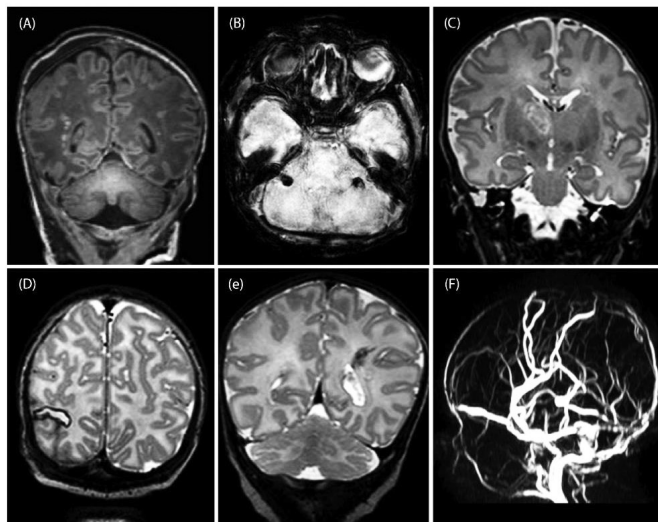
Brain injury visible on MRI in term infants. A, cT1, 5 days after gastroschisis repair:  $\geq 6$  punctate white matter lesions; B, SWI, 11 days after esophageal atresia repair: cerebellar hemorrhages; C, cT2, 5 days after bilateral megaureter repair: thalamic infarction; D, cT2, 6 days after congenital lobar emphysema resection: occipital hemorrhagic infarction; E, cT2, 6 days after tongue cyst repair: periventricular hemorrhagic infarction; and F, magnetic resonance venography, 20 days after gastroschisis repair: sinovenous thrombosis.
